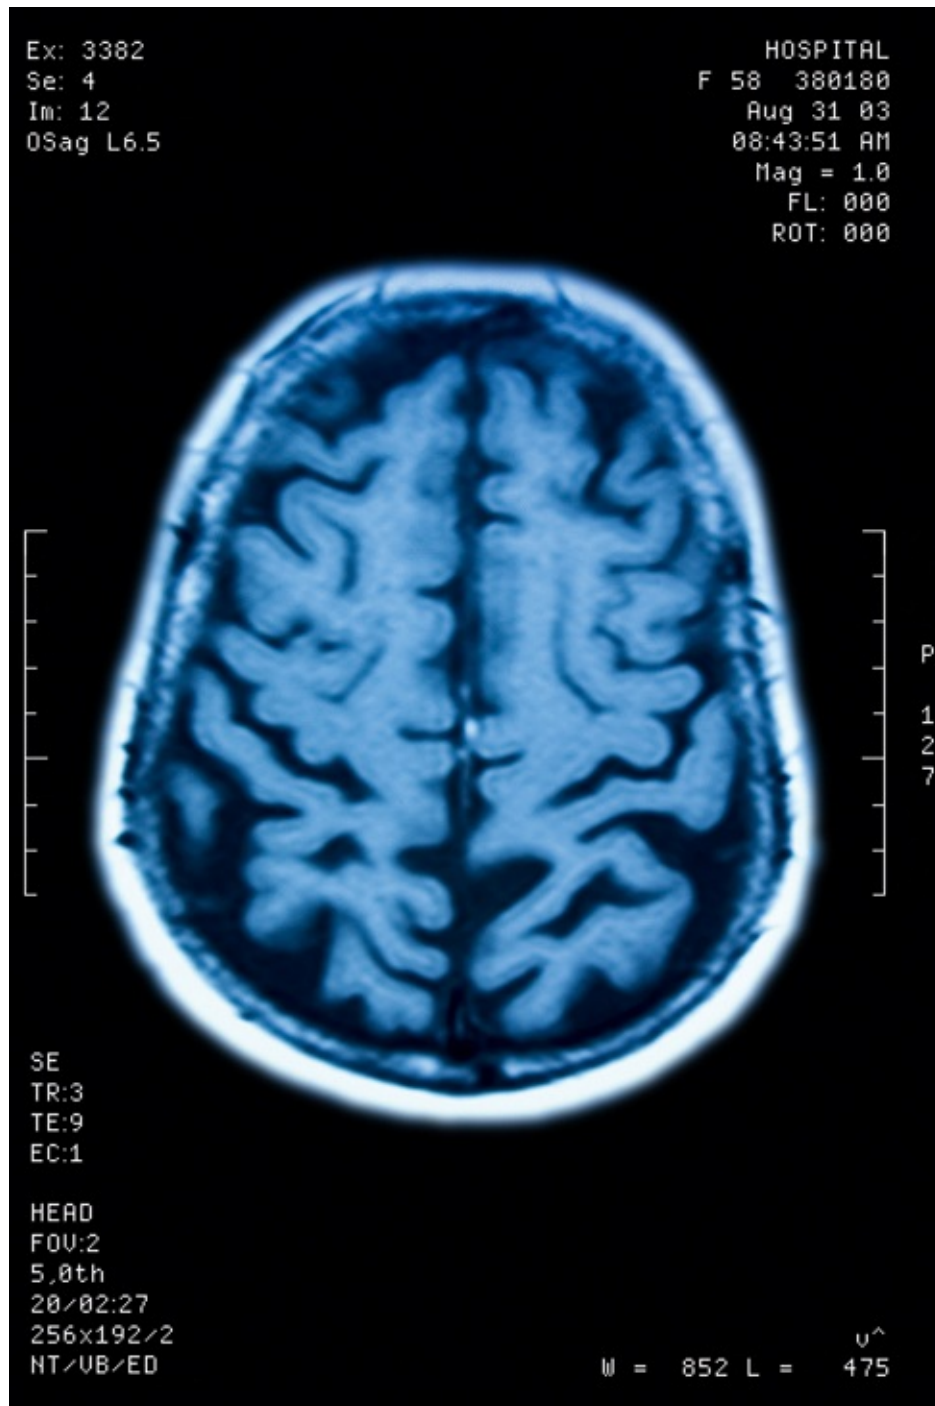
An MRI Scan of the Brain*
